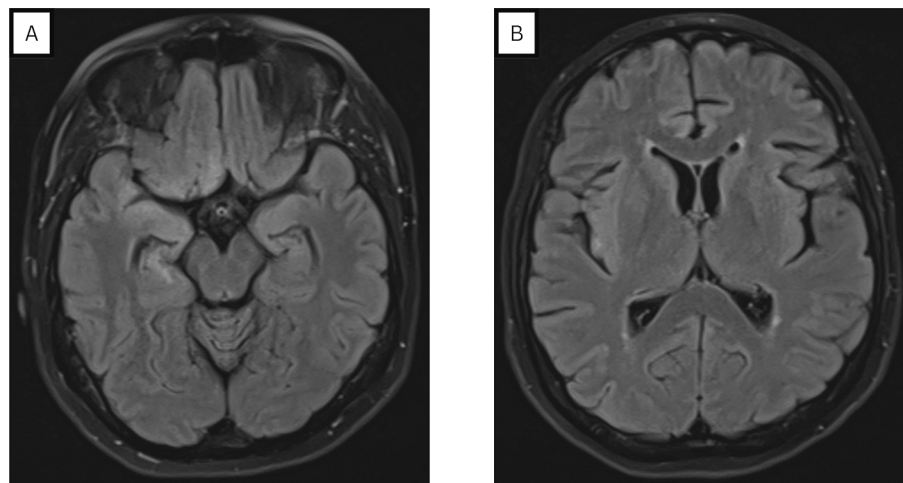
Axial T2/FLAIR brain MRI revealed confluent hyperintense signal changes in both mesial temporal regions (image A) and insular cortices (image B) as well as gyri recti with some localized swelling more seen on the right side.
